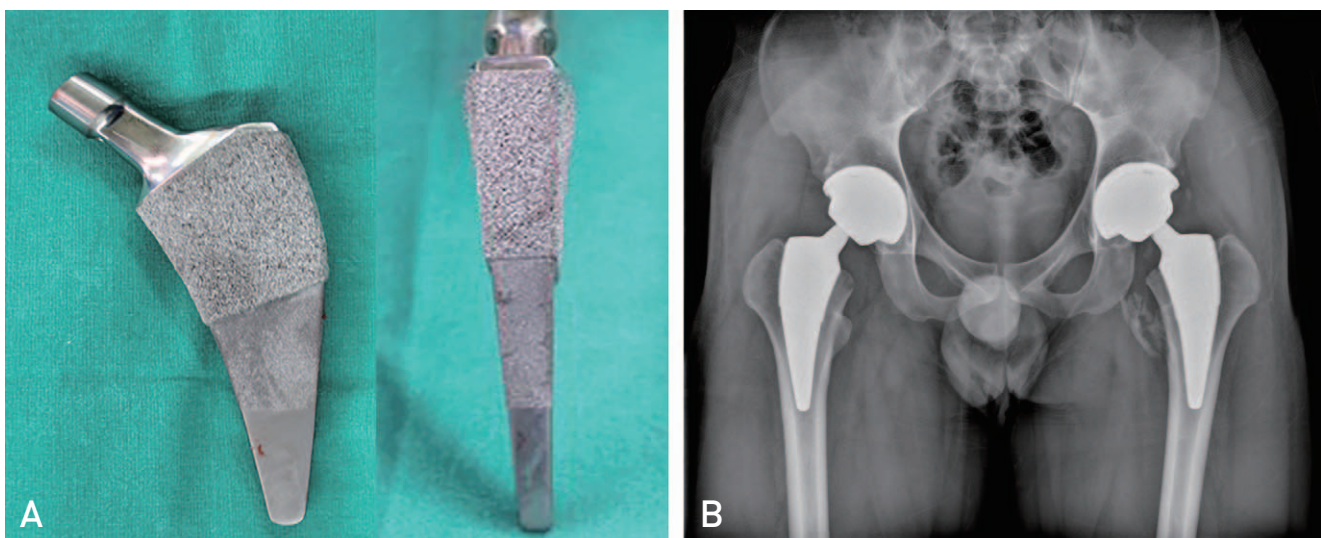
[A, B] Photos of SMF (Short Modular Femoral; Smith & Nephew) stems and a radiograph of both hips taken seven years after the operation.
